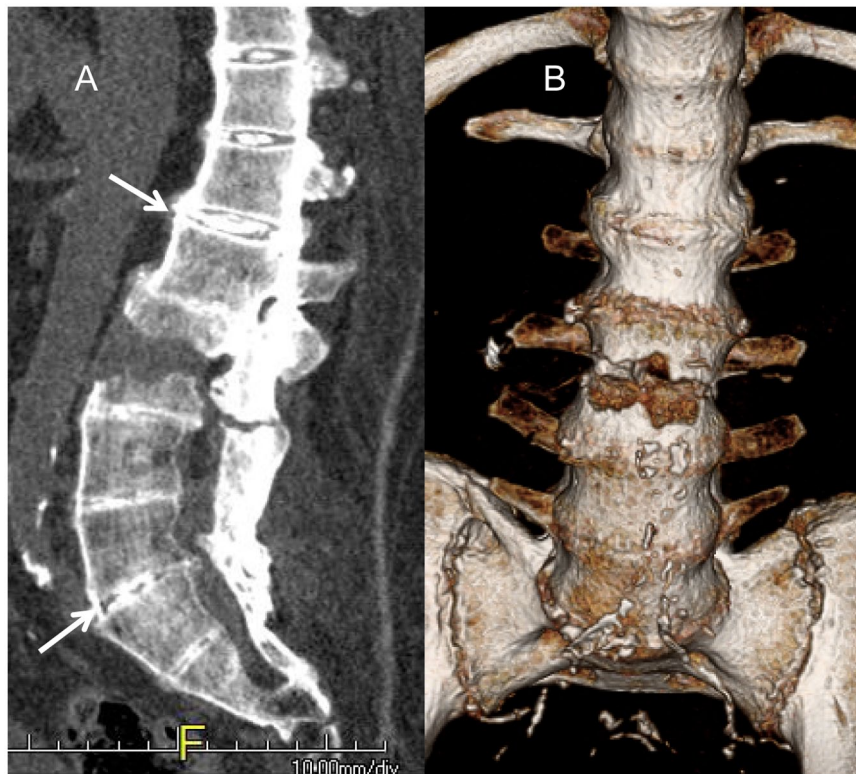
A 68-year-old man presented to the emergency department with severe low back pain after a fall in the shower. He had a long history of alkaptonuria and ochronosis with joint replacements of bilateral hips, knees, and the left shoulder. CT midsagittal (A) and (B) coronal images showing complete ankylosing of the facet joints, calcification of the intervertebral disc as well as anterior and posterior ligaments, with three columns unstable hyperextension injury of L3. The sacroiliac joints are not fused which differentiates ochronotic spondyloarthropathy from ankylosing spondylitis.
